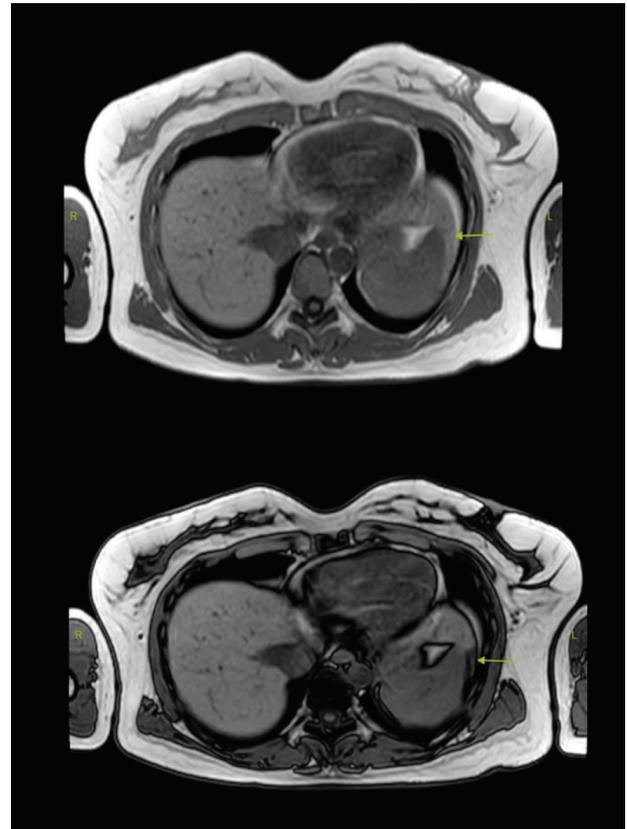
Liver lesion shows the loss of signal intensity between the in-phase and out-of-phase T1-weighted image.
